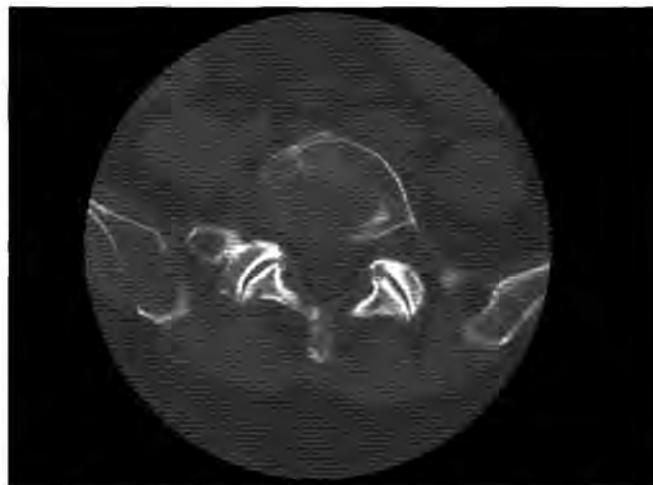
Axial CT images through the iliac crest demonstrate a lytic lesion in the right posterior iliac crest.
